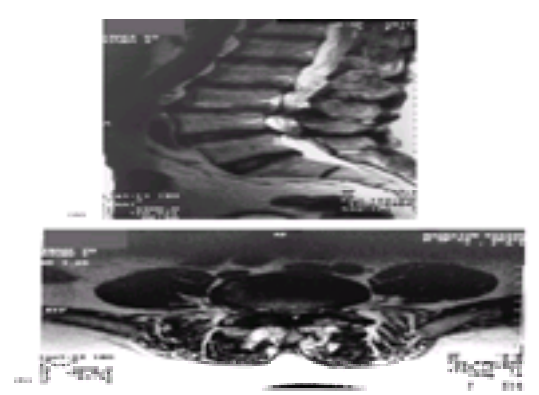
MRI scan to show stenosis of the lumbar canal due to facet-joint hypertrophy and osteophyte formation: sagittal (a) and axial (b) views.
